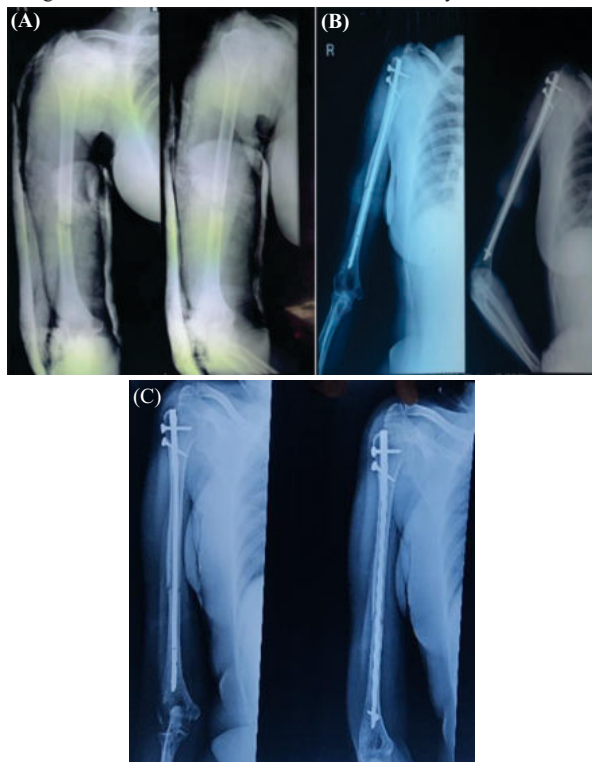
A case of Antegrade Nailing (A) Pre OP X-ray (B) Post Op X-Ray (C) Follow up X-ray
